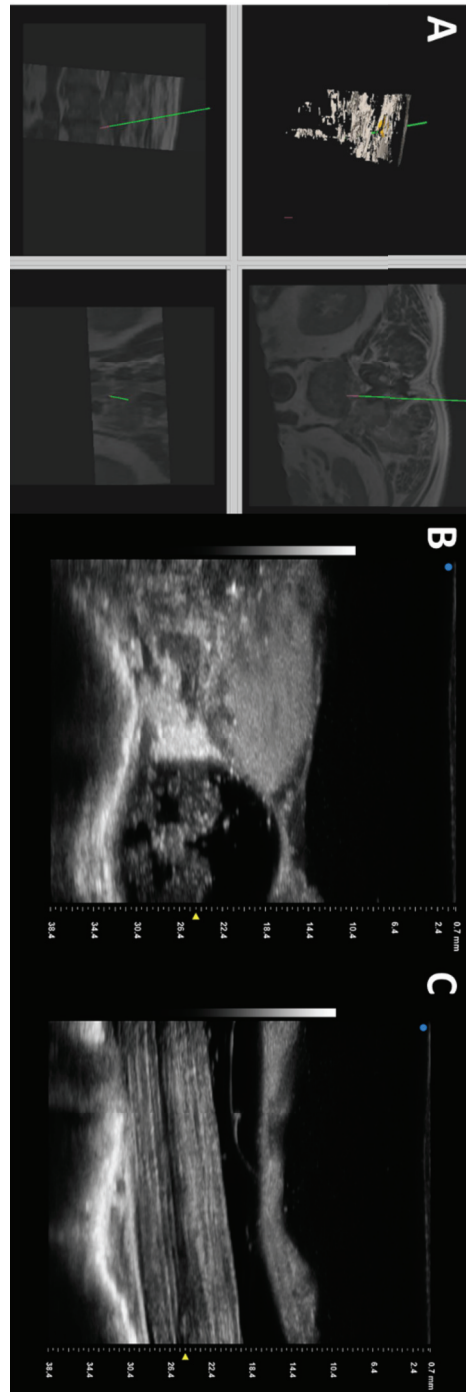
Patient 4: Tracked  $\mu$ US – Tracked axial and longitudinal intraoperative high frequency  $\mu$ US images acquired at 30 MHz. A) Tracking information and trajectory (Green Line) of the ultrasound probe as tracked by the navigation system. B,C) Representative axial and longitudinal  $\mu$ US images.
